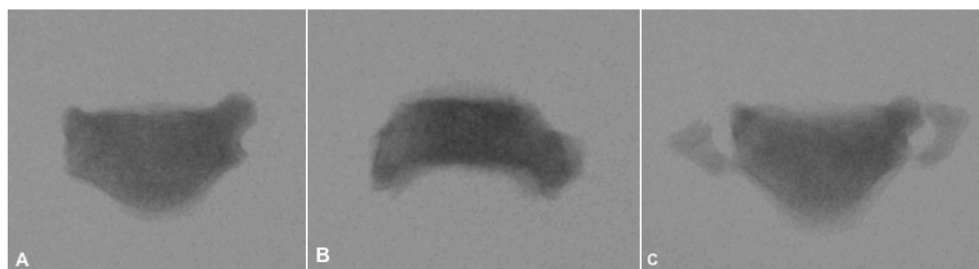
Intraoperative radiograph of the resected C3 vertebral body: (A) View of the upper endplate (B) View of the lower endplate (C) Detailed view to the osteotomy of the transverse foramen bilaterally.
